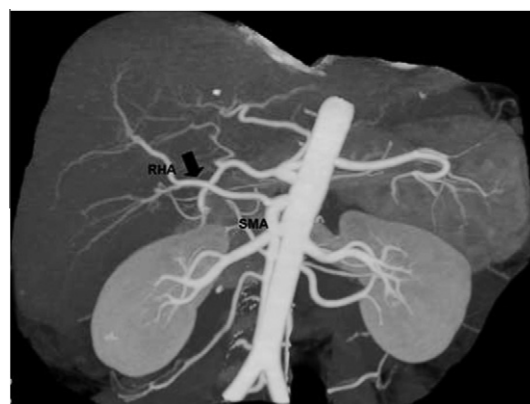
(MIP) image from CT data shows a replaced right hepatic artery RHA (arrow) arising from the superior mesenteric artery (SMA). Michel type III.
